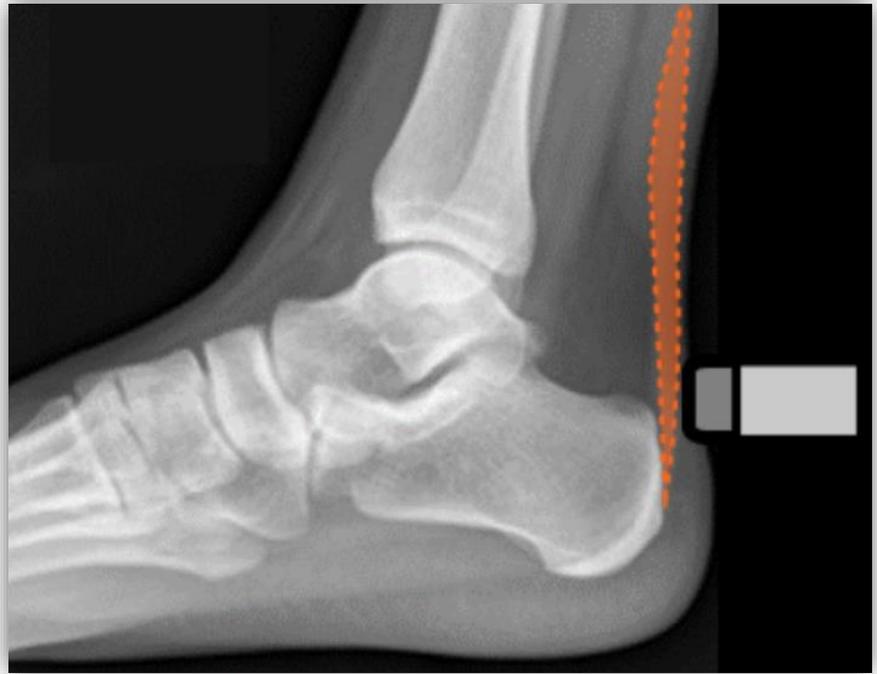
Lateral radiograph demonstrating the transversely oriented US transducer positioned just superior to the calcaneus, overlying the Achilles tendon (orange dashed outline).
